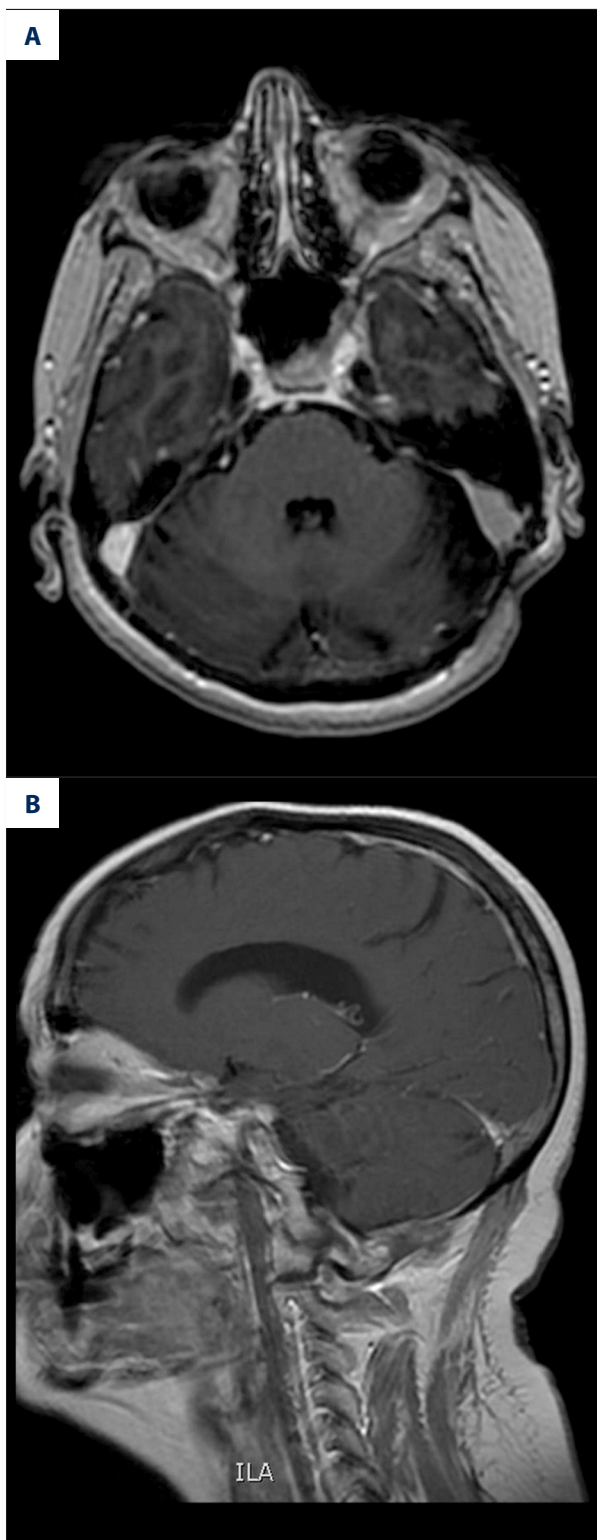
Postoperative axial (A), sagittal (B), and coronal (C) magnetic resonance imaging (MRI) scans with contrast showing no recurrence of the lesion at 2-year follow-up.
